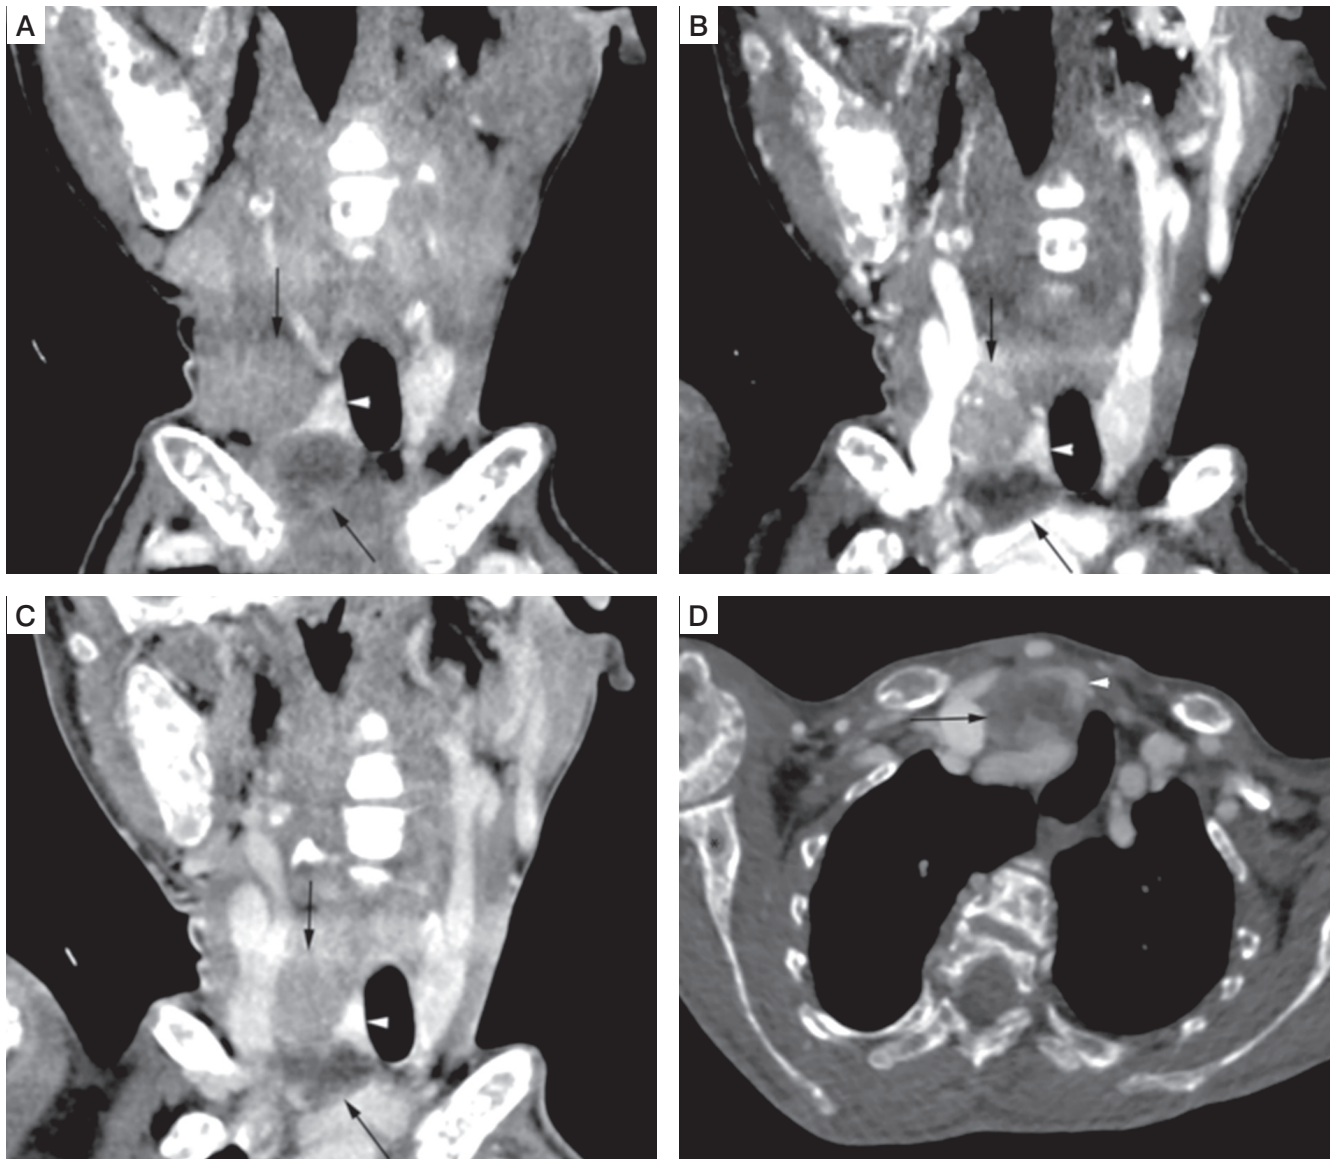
4-dimensional computed tomography (4D CT) scan of the neck. Coronal non contrast (A), arterial phase (B), and venous phase (C) CT images showed right superior and cystic right inferior parathyroid adenoma (black arrows), deep to right lobe of thyroid gland (white arrowhead). Right superior parathyroid adenoma, and peripheral enhancing regions of cystic right inferior parathyroid adenoma appear hypodense to thyroid gland on non-contrast CT images, with enhancement in arterial phase and relative washout in venous phase. Axial venous phase CT image (D) shows cystic right inferior parathyroid adenoma (black arrow) deep to right lobe of thyroid gland (white arrowhead). Brown tumors also noted in right proximal humerus, and right scapula (black asterisks)
